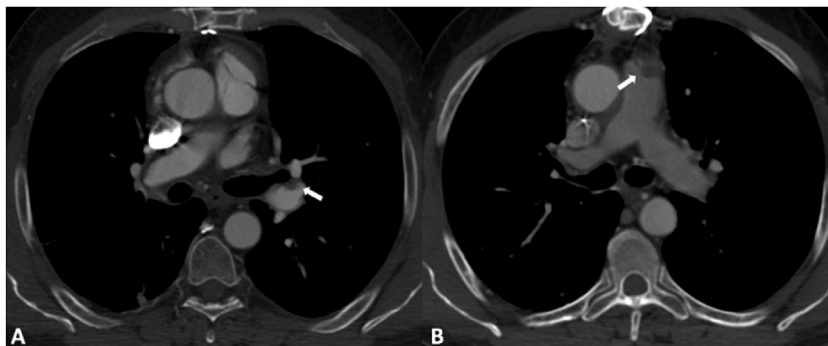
"Cauliflower-like" morphology. Axial CT images demonstrate the presence of endoluminal filling defects, with adherence to the wall and convex and finely irregular morphology on the luminal side (white arrows in A and B). This aspect is very specific to PAIS.
